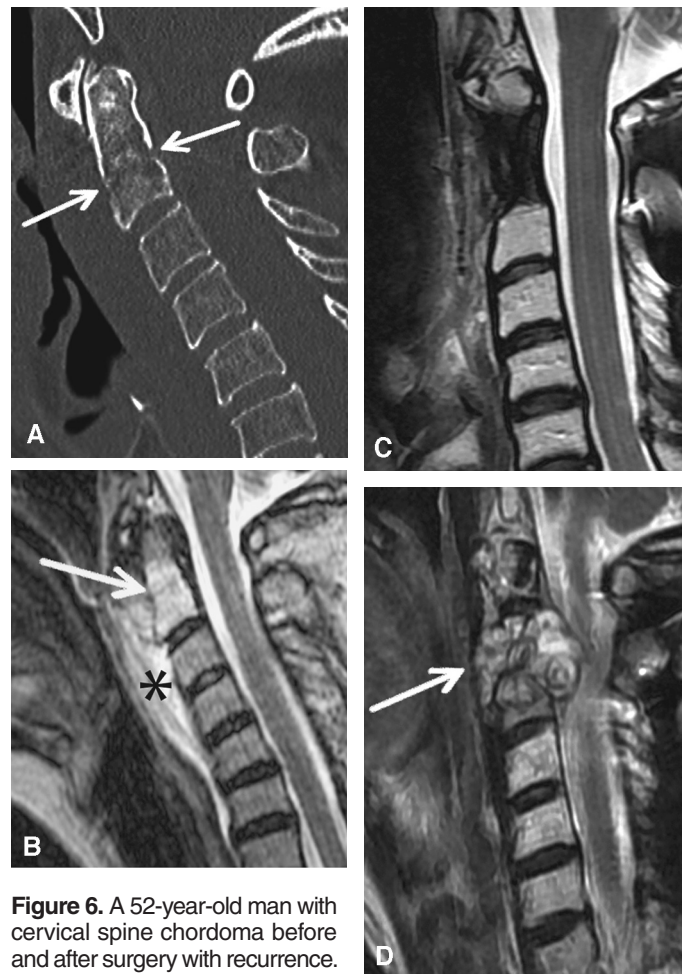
A 52-year-old man with cervical spine chordoma before and after surgery with recurrence. A: Preoperative sagittal CT scan shows subtle cortical irregularity and permeation of C2 body extending into odontoid process (arrows). B: Preoperative sagittal, T2-weighted MR image shows high signal of C2 (arrow) with C2-C6 prevertebral soft tissue thickening (asterisk). C: Sagittal, T2-weighted MR image shows no recurrence 2 years after surgical resection and fusion from occiput-C4. D: Sagittal, T1-weighted, postcontrast MR image 1 year later shows recurrence with new lobulated, heterogeneous signal at the surgical site (arrow) expanding into the ventral central spinal canal.
